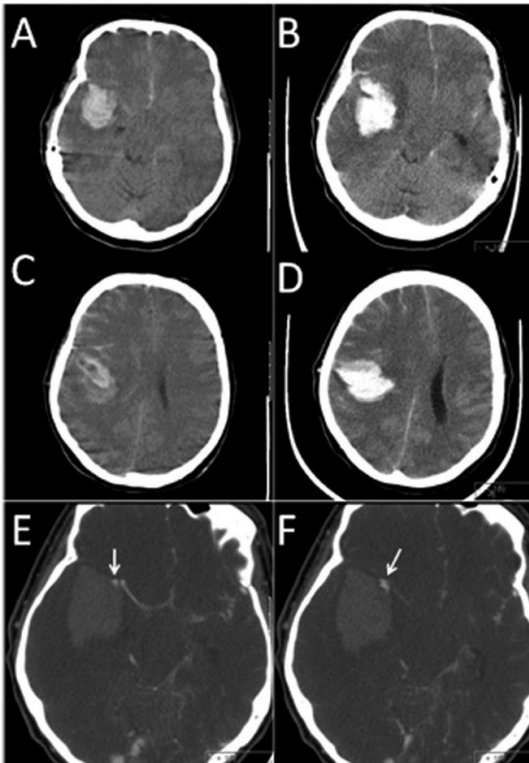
A 53-year-old man was admitted with SAH and a right temporal ICH adjacent to the sylvian fissure (A and C; the first CT was performed at a regional hospital). Initially, his clinical condition was stable, with a Glasgow Coma Scale score of E3M6V3 and a left-sided paralysis. A few hours later, the patient had to be intubated because of sudden neurologic deterioration accompanied by progressive respiratory failure; he was then transferred to our hospital. Subsequent CTA showed active extravasation (E and F, second CT; the arrow indicates contrast leakage into the haematoma) from a middle cerebral artery aneurysm into the expanding ICH (B and D, second CT). His neurologic condition worsened to a Glasgow Coma Scale score of E1M1Vtube with bilateral, fixed, dilated pupils and brainstem dysfunction, and he died soon after admission.
